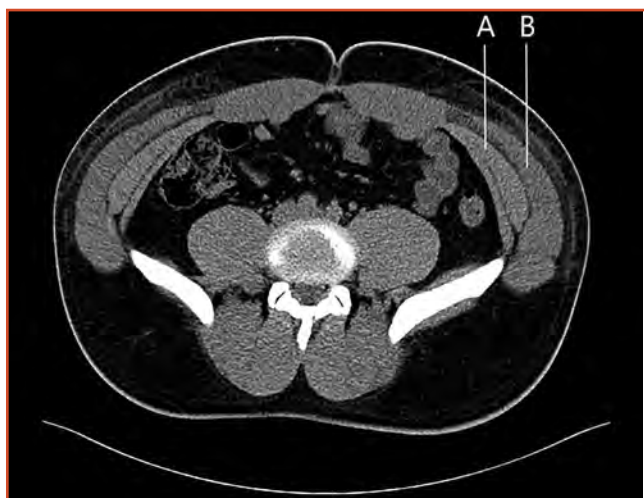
Axial view of abdominal computed tomography scan, showing intramuscular edema and inflammatory stranding of internal oblique (marked with “A”) and external oblique (marked with “B”) more prominent on the left side.
